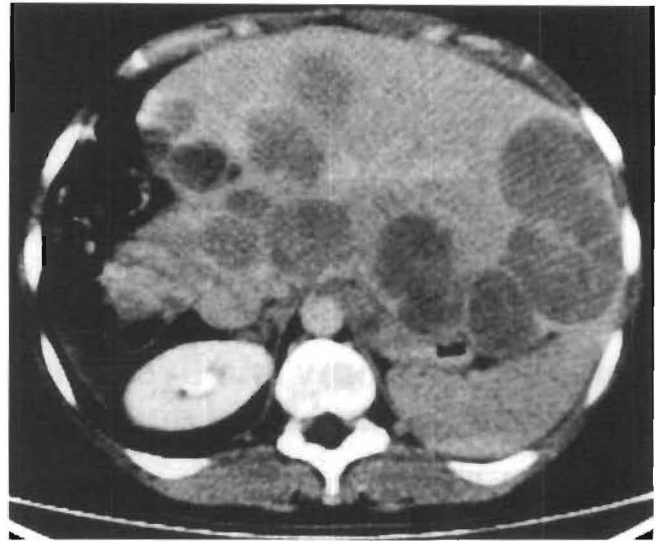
Pre OLTx CT scan, case no. 1. Multiple hepatic masses occupying almost all the liver parenchyma
